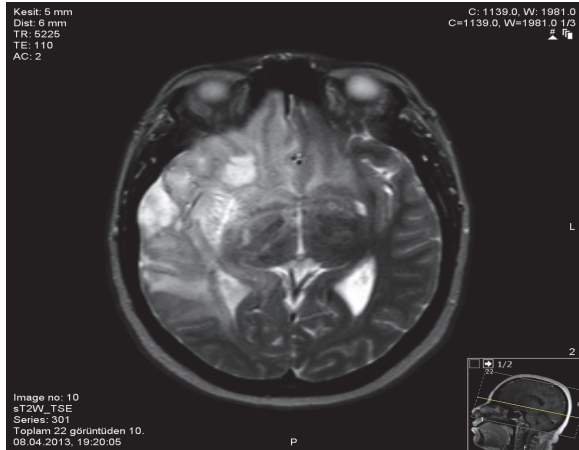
The MRI view of Case 1.
